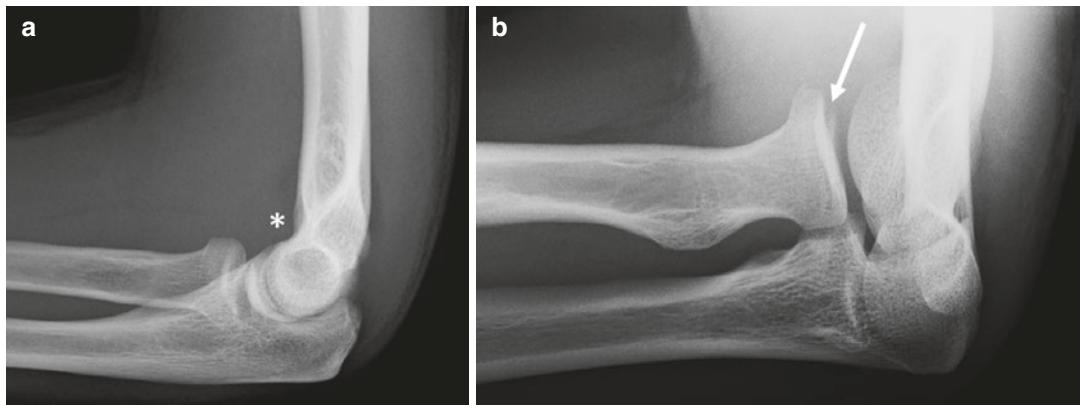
Thirty-three-year-old man with a non-displaced radial head fracture. Lateral radiograph (a) demonstrates an elbow effusion (asterisk) without a fracture identified. Radial head-capitellum view (b) shows a non-displaced radial head fracture (arrow)
